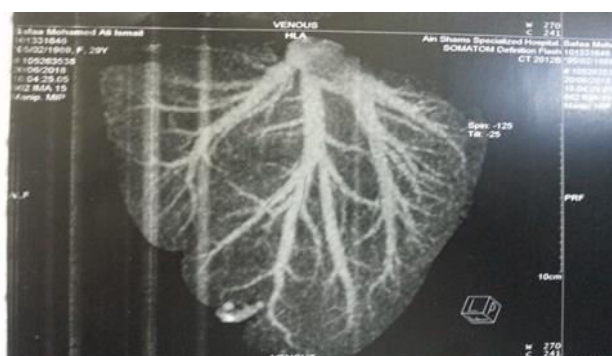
CT volumetry of a donor showing a significant area drained through V5.
